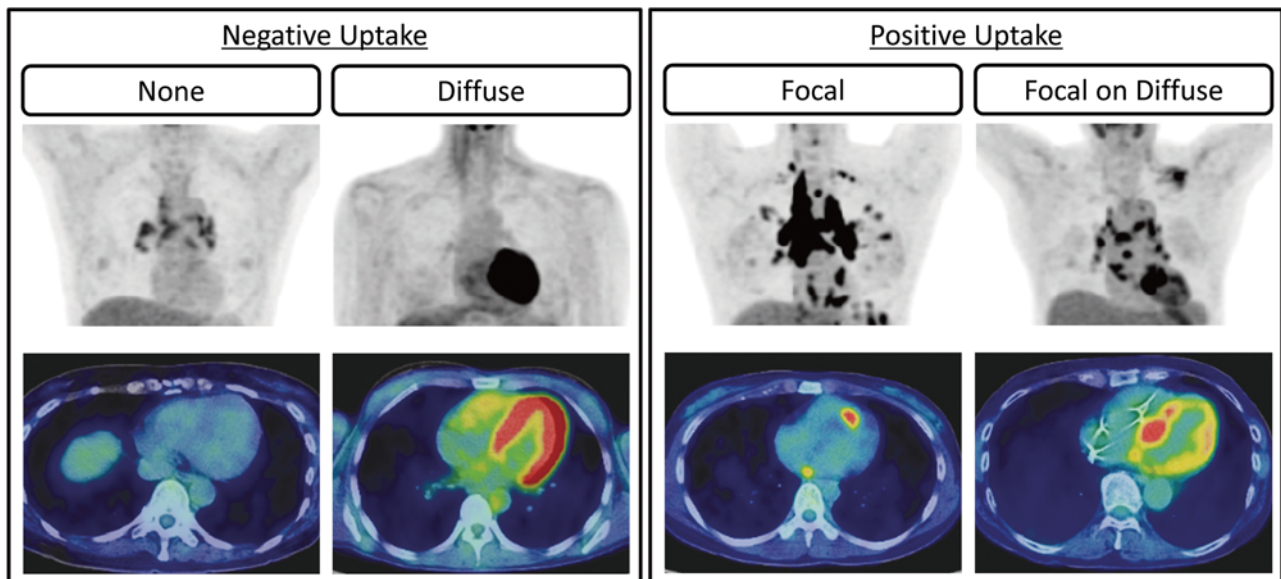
Definition of positive ¹⁸F-FDG uptake in diagnosis of cardiac sarcoidosis
